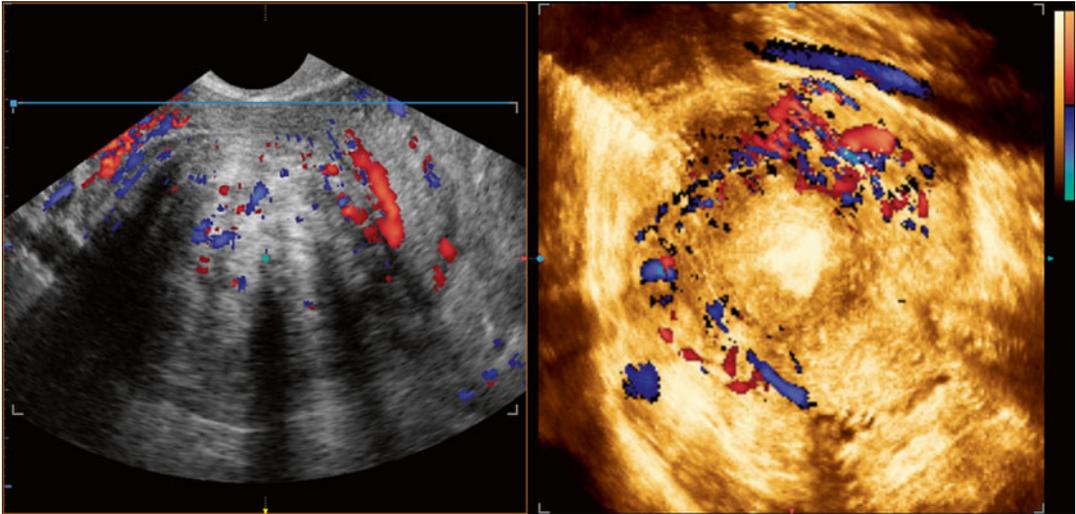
Vessels around a fibroid with ultrasound greyscale combined with colour doppler
